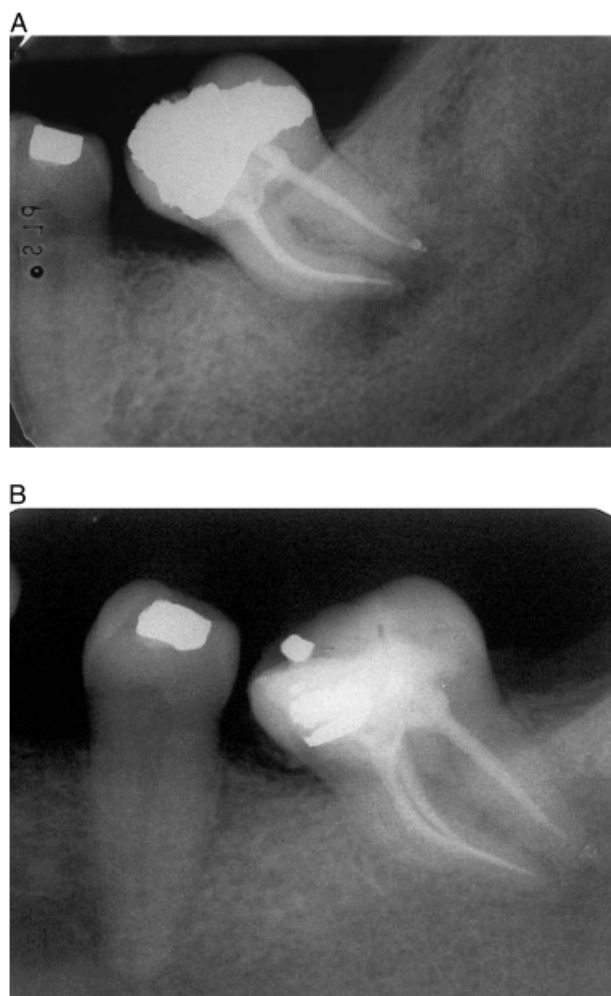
Mandibular molar diagnosed with periradicular periodontitis treated using GT hand files. Note significant curvature of mesial root. (A) Postoperative radiograph. (B) follow-up radiograph.
